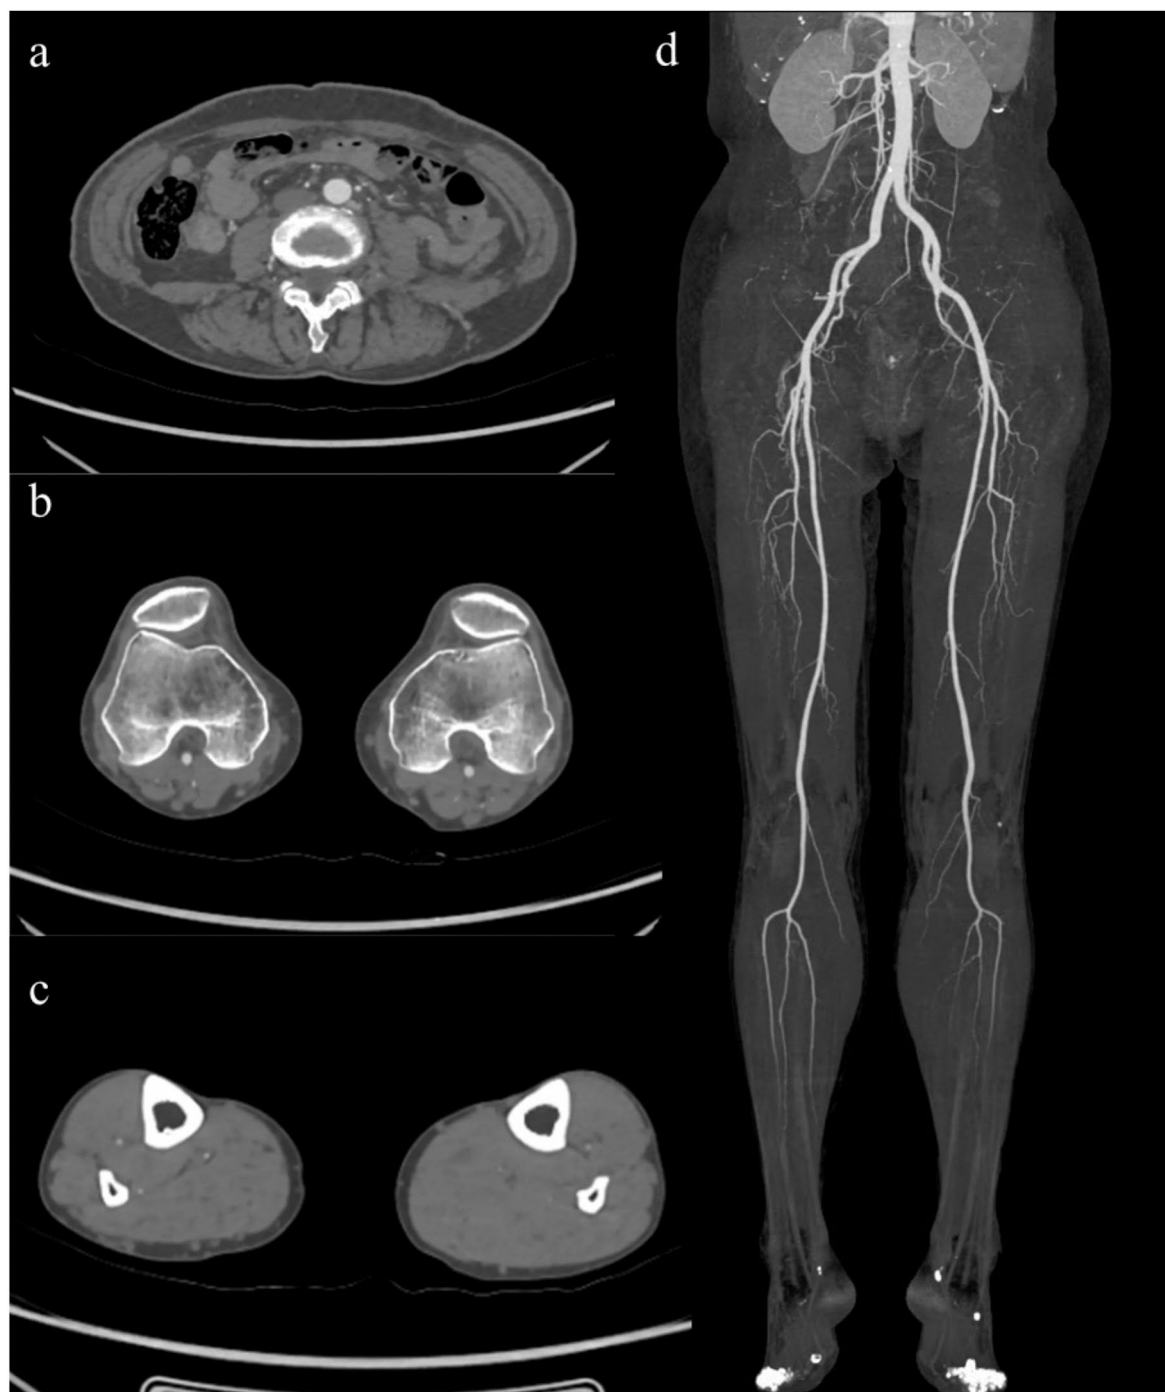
A 70-year-old male patient with a history of smoking and intermittent claudication in the right lower limb underwent routine lower limb artery CTA (abdominal aorta monitoring). (a) Show abdominal liliac segment. (b) Show femoral popliteal segment. (c) Show lower knee segment. (d) Show maximum intensity projection of peripheral arteries. The overall image quality was moderate, with insufficient contrast enhancement in the LKS region. A senior physician diagnosed no significant abnormalities in the lower limb arteries, while the junior physician had low confidence in the LKS diagnosis. Subjective scores were AIS: 4, FPS: 3, LKS: 3, with a lower limb vessel grading of 2. Diagnostic confidence levels were AIS: 3, FPS: 3, LKS: 1.
